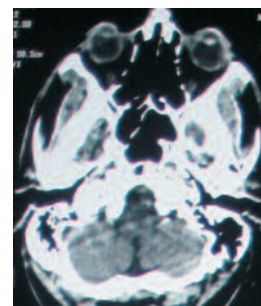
Axial CT- showed no abnormality
